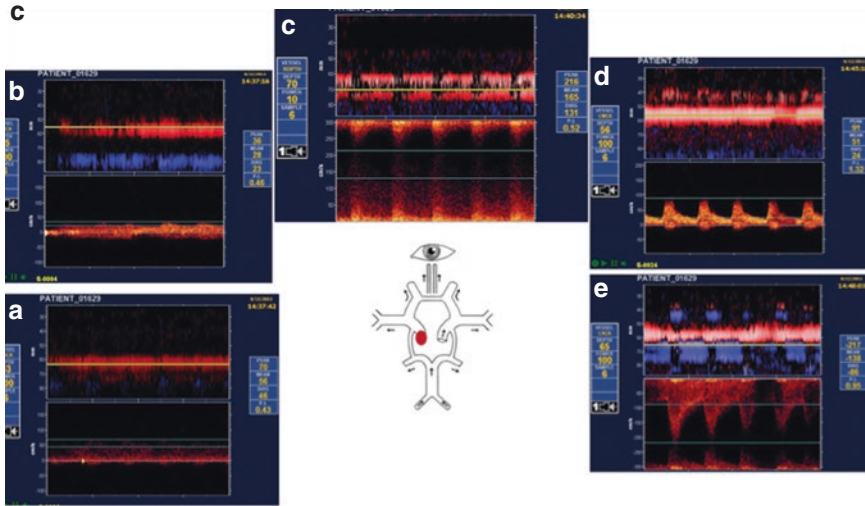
Anterior Communicating Artery signature (AcomA) on Transcranial Doppler and Power M Mode Doppler; Panel (a) Anterior Communication Artery signature through the temporal window at 70–80 mm depth (stenotic signal away from the probe on the donor side); Panel (b): AcomA flow through the orbital window at depth 60–70 mm (stenotic signal toward the probe on the recipient side); Panel (c): Collateral blood flow through anterior communicating artery in the presence of internal carotid artery critical stenosis: (a) delayed flow acceleration of ipsilateral middle cerebral artery (MCA), (b) ipsilateral reverse anterior cerebral artery (ACA) flow, (c) AcomA flow, (d) normal flow in the contralateral MCA, (e) donor ACA
